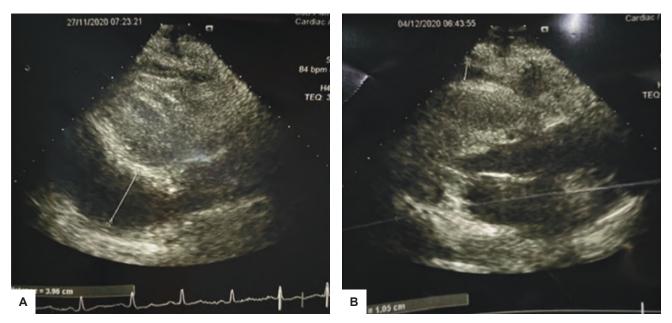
(A) Transthoracic echocardiogram parasternal long axis view of Case 2 demonstrating pericardiac effusion of 3.96 cm. (B) Transthoracic echocardiogram parasternal long axis view showing reduction in pericardial effusion size.
